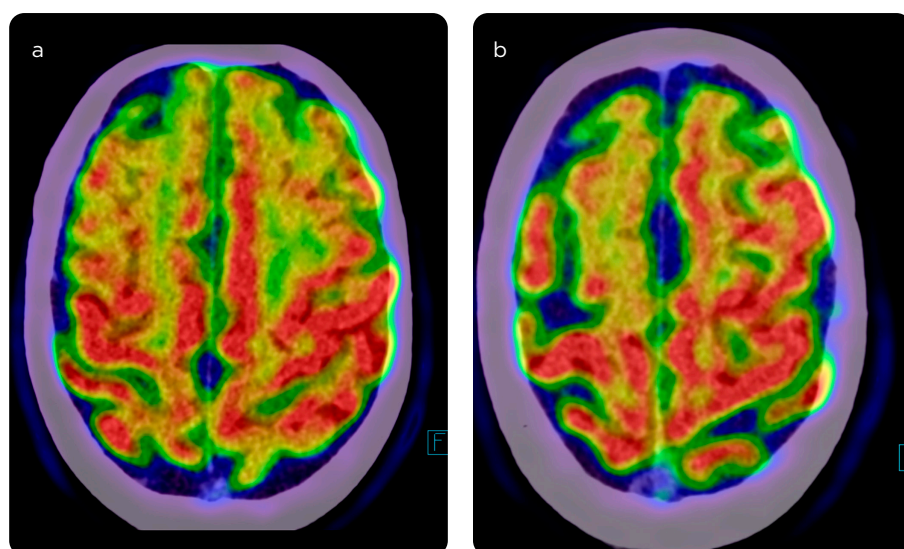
a, b) Axial slices of 18F-FDG-PET/CT image showing areas of hypometabolism in bilateral frontal cortex, right predominant.
